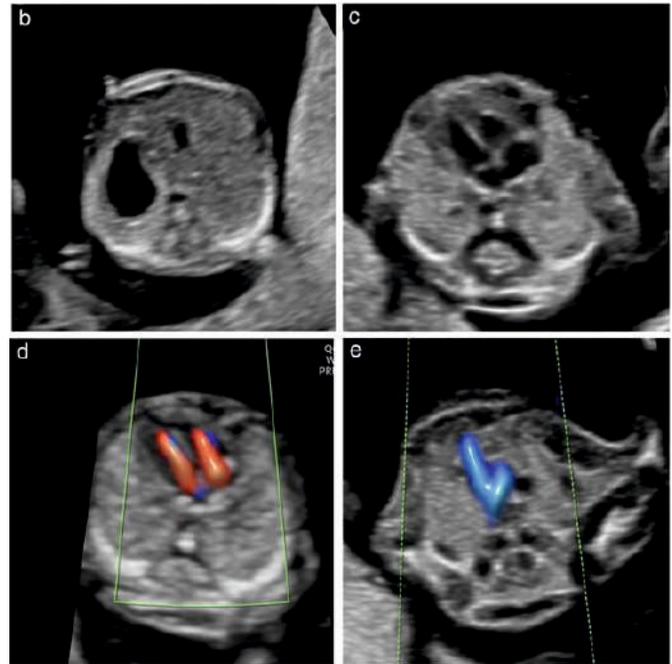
Cardiac examination in early gestation should focus on these selected planes: demonstration of cardiac axis and abdominal situs with stomach on left side, four-chamber view (color doppler) during diastole and three-vessel-and- trachea view (color doppler) during systole.
